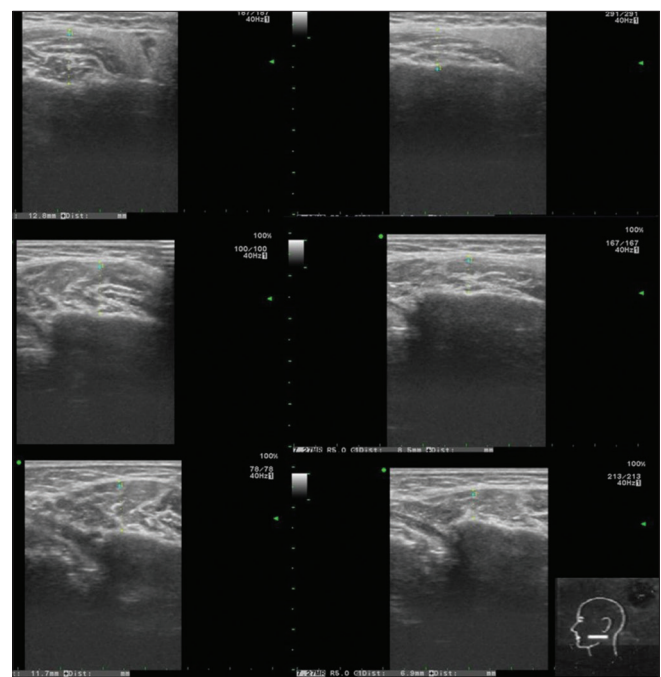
USG image of the left masseter muscle at RST and MVC. USG: Ultrasound, MVC: Maximum voluntary contraction, RST: Rest
